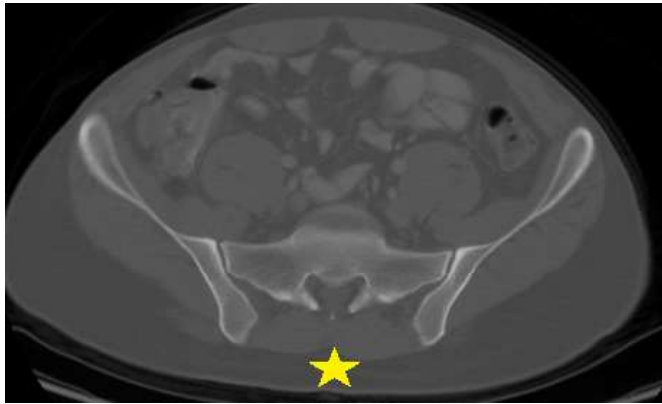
CT scan of the pelvis showing a failure of fusion. As shown (by the star), there is a gap in the posterior aspect of the spinal canal. (Case courtesy of Dr Hani Makky ALSALAM, Radiopaedia.org, rID: 8909)
